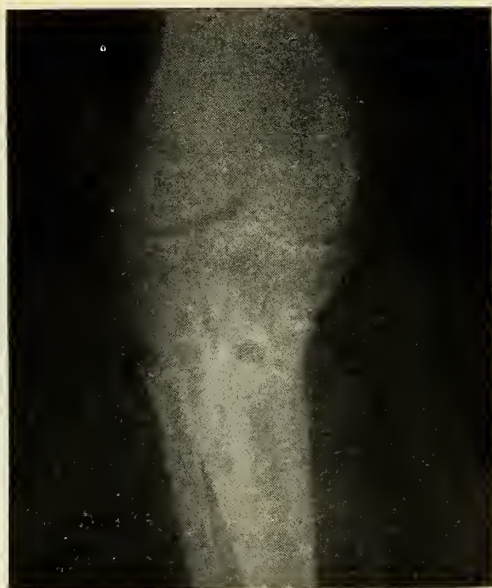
X-ray taken nine months after fat transplantation showing considerable new bone formation.
